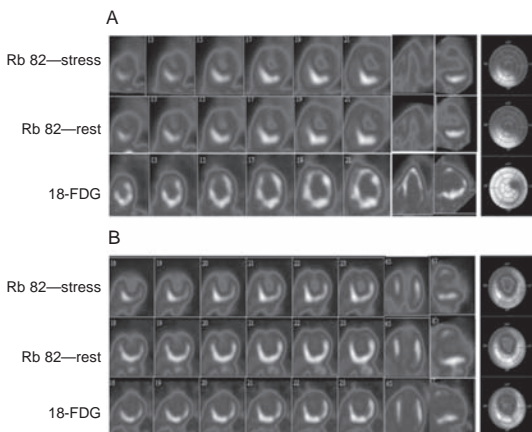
Rubidium PET followed by FDG PET: Patient A showing metabolism mismatch and is indicative of hibernating, viable myocardium. Patient B showing impaired FDG uptake combined with reduced perfusion (flow–metabolism match) is indicative of myocardial scar.
